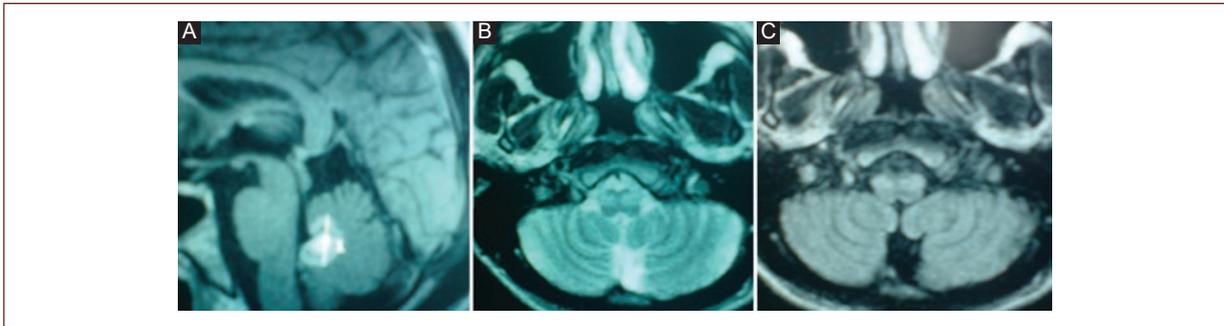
(Patient 20) Magnetic resonance imaging (MRI). Ring enhancement on sagittal T1 contrast-enhanced weighted imaging in the fourth ventricle A: consistent with toxoplasmosis in a patient with HIV, axial T2 B: and FLAIR C: with olivary hypertrophy 11 months after follow-up.
